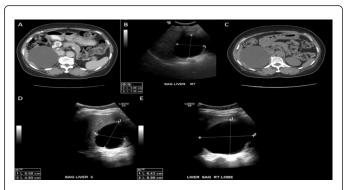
A) Contrast enhanced CT on 5/6/11 demonstrating a right inferior hepatic lobe cyst measuring 9.4 × 8.5 cm, (B) Ultrasound on 4/5/12 showing decrease in right hepatic lobe cyst following aspiration on 7/11/11, (C) Follow-up unenhanced axial CT on 1/13/13 demonstrating reaccumulation of the right hepatic lobe cysts measuring 10.4 × 9.1 cm, (D) Follow-up ultrasound on 6/5/13 showing decrease in size following repeat aspiration 2/25/13, (E) Subsequent ultrasound on 2/27/14 again showing reaccumulation.
